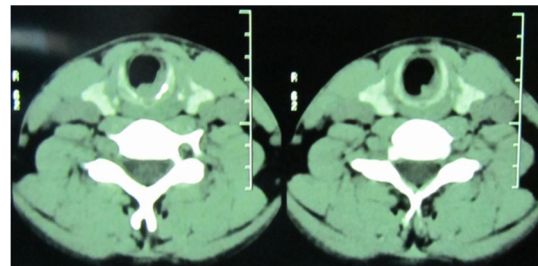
The patient's CT-scan which shows a subglottic mass
